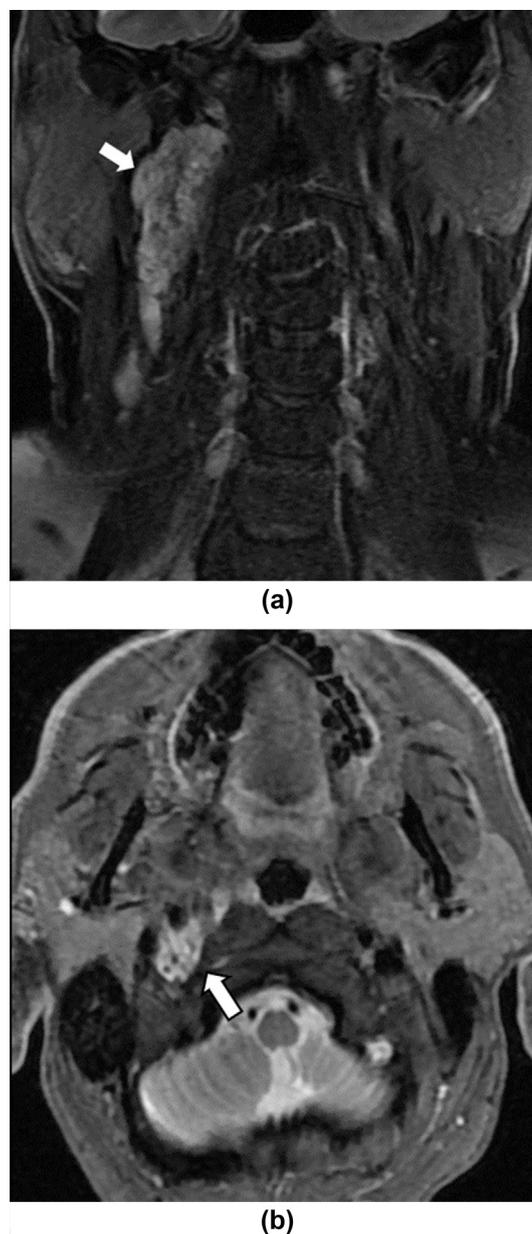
(a) Coronal T2 fat saturation MRI image of 42-year-old man with paraganglioma syndrome 4 undergoing surveillance imaging demonstrating a right vagal paraganglioma (arrow). (b) Axial T2 MRI image showing the vagal paraganglioma tracking along the carotid sheath towards the jugular foramen.
